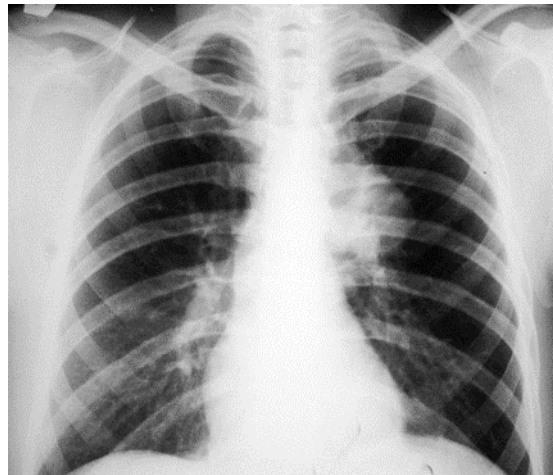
Chest radiography shows a tumor in the left lung.
